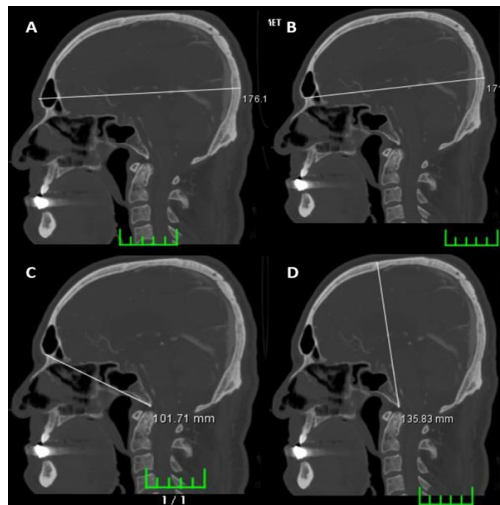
Demonstration of maximum cranial length (A), naso-occipital length (B), cranial base length (C), and basion–bregma length (D) on sagittal and axial CT sections.
